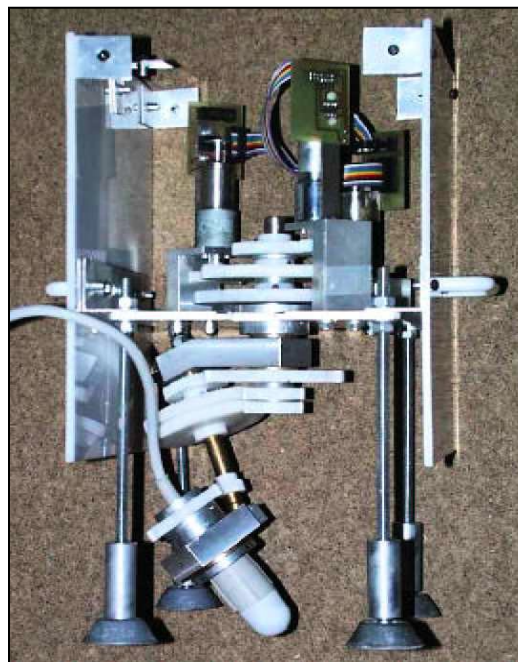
SYRTECH Device with Ultrasound Probe
